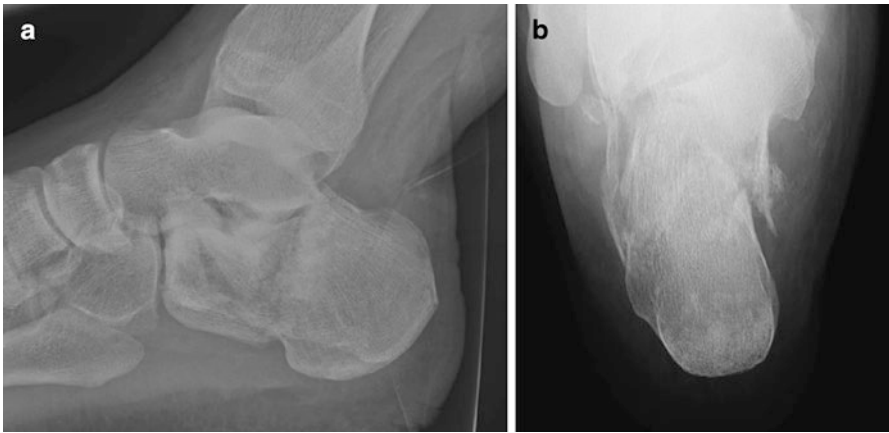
(a) Lateral radiograph of the heel (b) Harris heel radiograph
